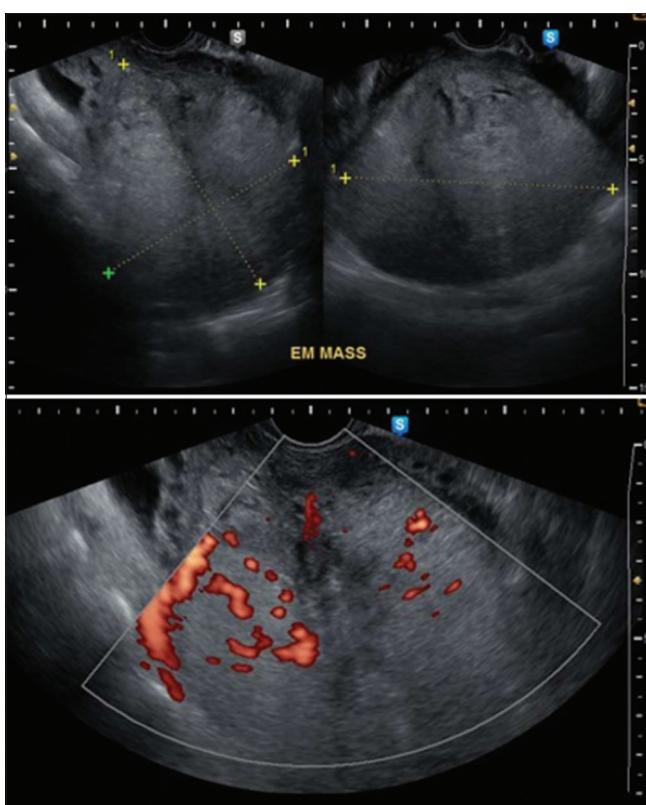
Endometrial mass on transvaginal ultrasound
